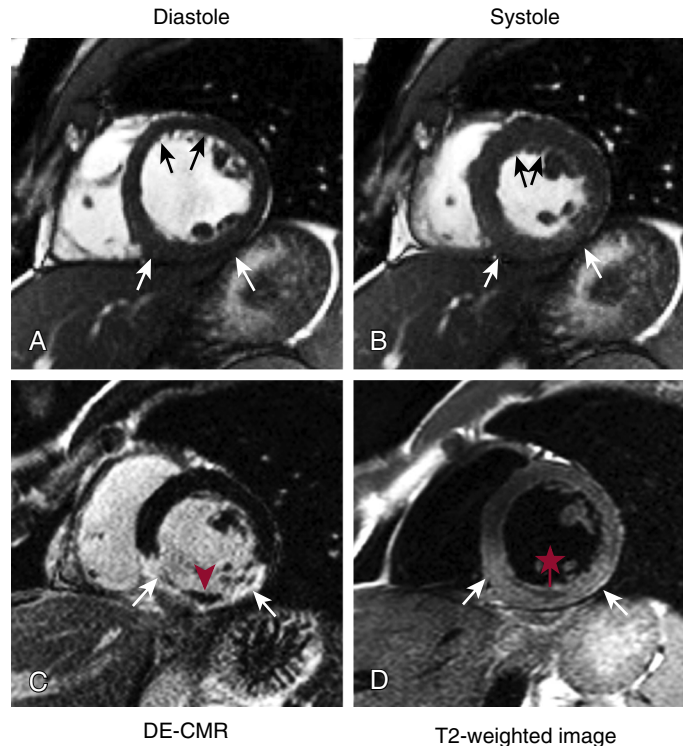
Cine steady-state free-precession images in (A) diastole and (B) systole from a patient with an acute inferior myocardial infarction. The inferior, inferoseptal, and inferolateral segments, although thicker in diastole, do not show normal thickening (white arrows) compared with the noninfarcted anterior wall (black arrows), which demonstrates normal systolic thickening. (C) The spatially matched delayed-enhancement cardiac magnetic resonance (DE-CMR) image shows a transmural infarction of the inferior wall and the inferoseptal segment (arrow). The small dark area in the center of the hyperenhanced inferior wall on the DE-CMR image is a no-reflow zone (red arrowhead) reflecting microvascular damage and the absence of gadolinium contrast uptake. (D) A T2-weighted image (pre-contrast) at the same location shows a high signal consistent with edema (arrows) and a low signal centrally in the infarct that corresponds to the no-reflow zone and represents coexisting intramural hemorrhage (red star), which results in lower myocardial T2 values.
